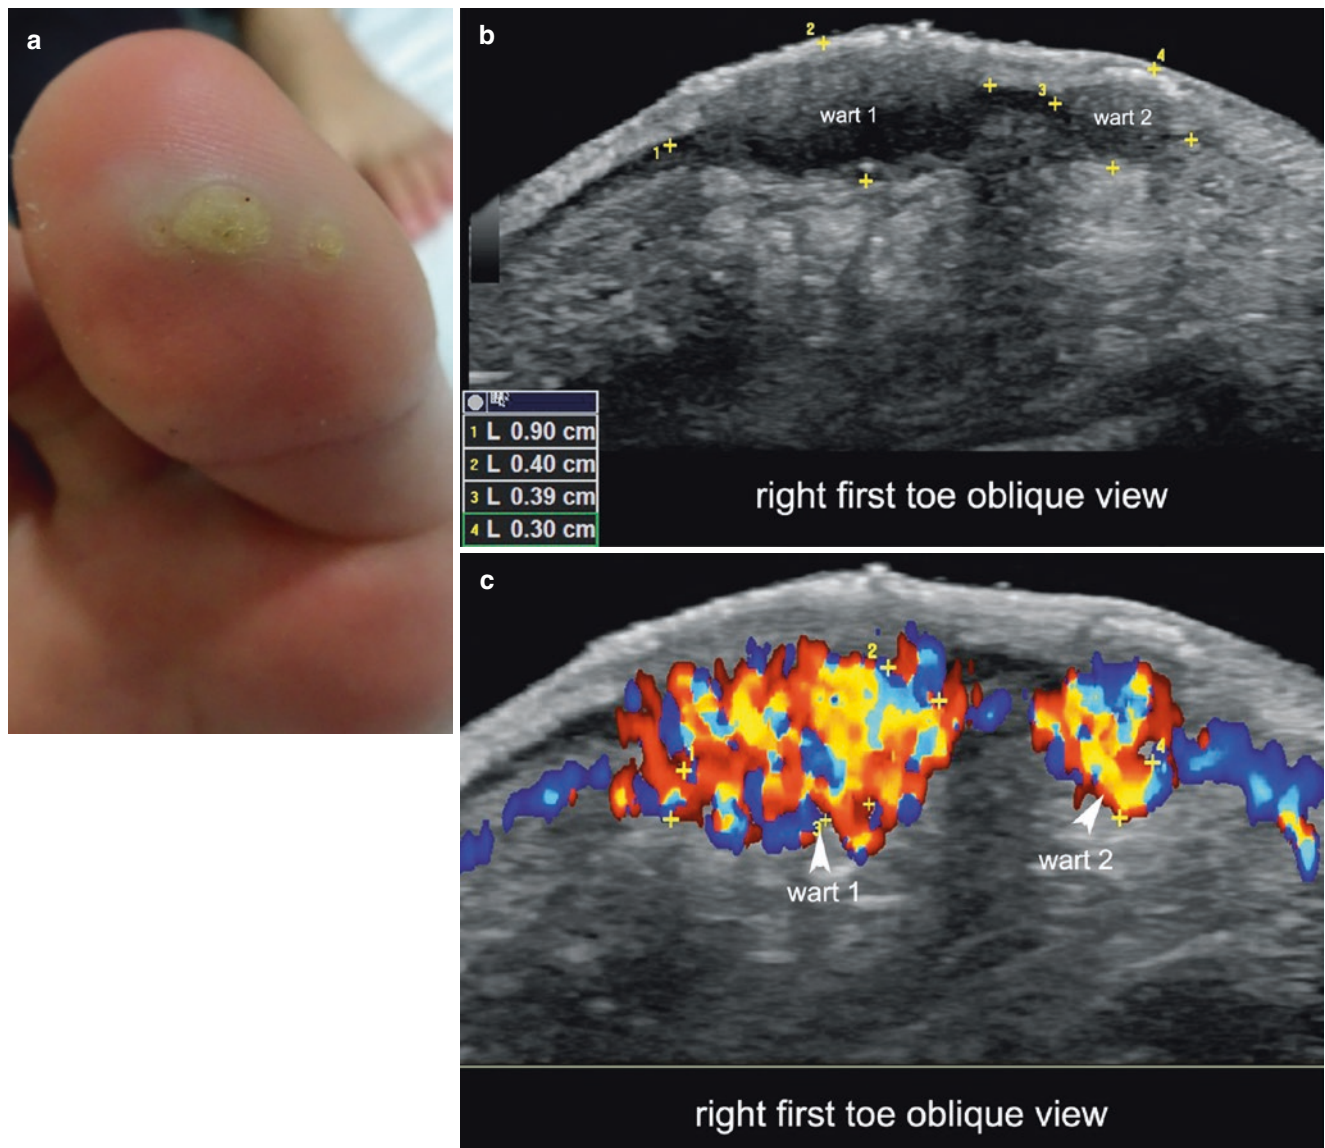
Two plantar warts. (a) Clinical lesion. (b and c) Ultrasound (oblique views following the axes of both lesions; right first toe; wart 1 and wart 2; (b) greyscale; (c) color Doppler) demonstrates two neighboring well-defined, hypoechoic, fusiform epidermal and dermal structures compatible with warts. The larger wart is more laterally located
